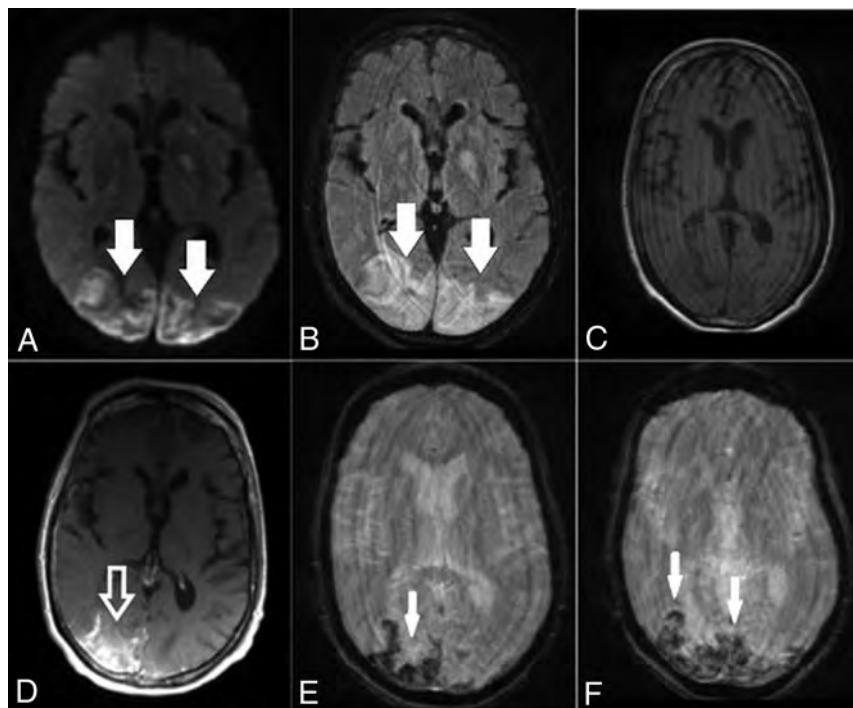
Brain axial DWI (A), FLAIR (B), precontrast T1-weighted (C), postcontrast T1-weighted (D), and susceptibility-weighted (E and F) images obtained 8 days after CT demonstrate a small infarct in the right occipital region (arrow, A), persistent edema in the posterior parieto-occipital regions (hollow black arrows, B), subacute blood products in the location of the infarction (solid white arrow, C), and some contrast enhancement (hollow white arrow, D). There are diffuse petechial hemorrhages on SWI throughout the corpus callosum (white arrows, E and F).
